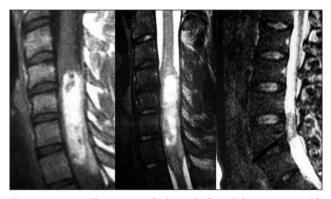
A well-circumscribed, oval shaped large mass with contrast enhancement at C4-7 levels on sagittal T1-weighted (left) and T2-weighted (middle) MRI images. A small, well-circumscribed, heterogeneous hypo-intense mass at L3-4 levels on sagittal T2-weighted MRI images (right).
